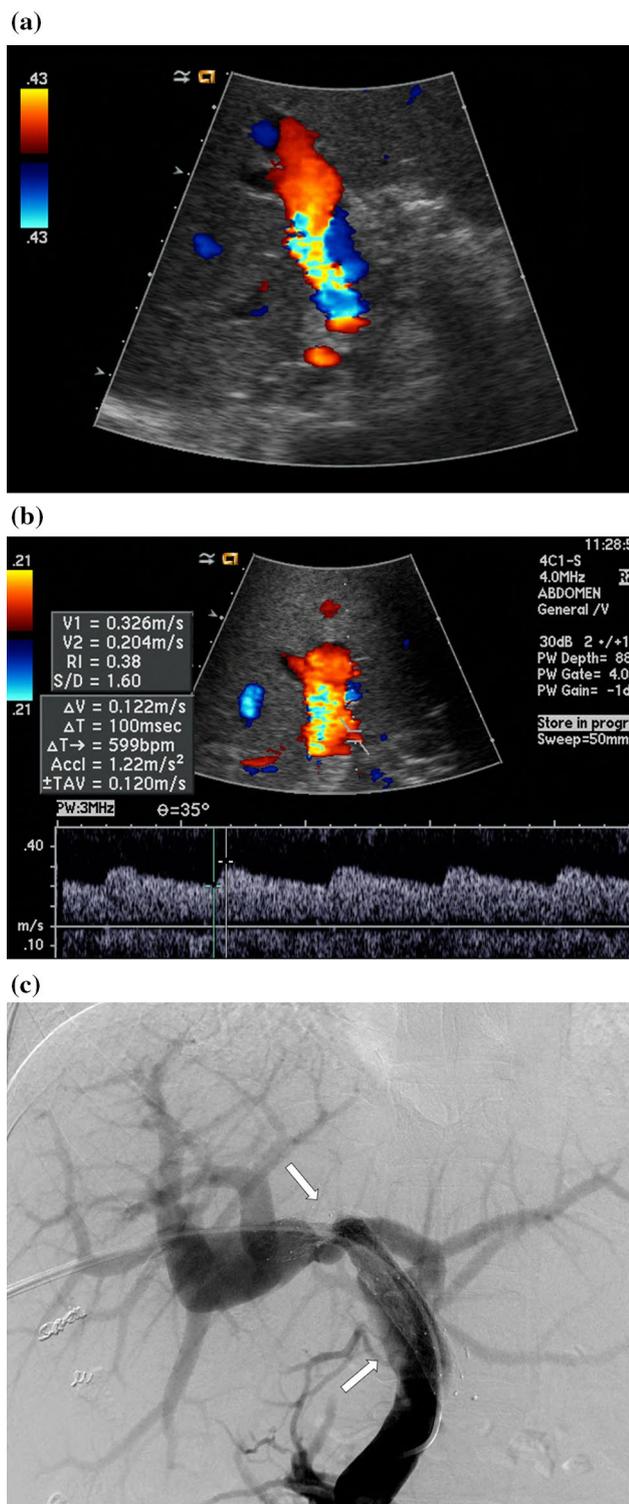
A 36-year-old female with portal vein thrombosis after whole liver transplantation from cadaveric donor. a Color Doppler sonogram shows turbulent flow in the graft portal vein. b Spectral Doppler ultrasound shows a tardus–parvus waveform at the graft hepatic artery, with a prolonged systolic acceleration time and low resistive index. c Portal venography shows a large filling defect representing thrombosis in the main and right main portal vein. The patient underwent portal vein thrombectomy and stenting. Along with portal vein flow restoration, Doppler sonogram showed disappearance of the tardus–parvus waveform at the graft hepatic artery (not shown)
